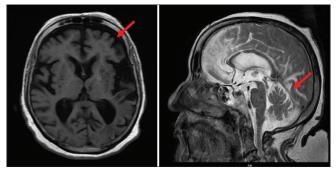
Magnetic resonance imaging brain is suggestive of diffuse cerebellar atrophy with marked frontal lobe atrophy
